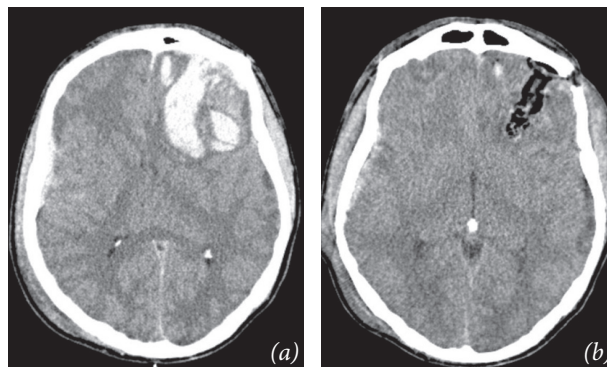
Non-enhanced CT scan in a 24-year-old male after physical assault and alcohol consumption; (a) GCS 3 with absent pupillary reactivity. Visible subarachnoid hemorrhage; (b) follow-up CT (24-hour): left-sided postoperative trepanation and hematoma evacuation.
